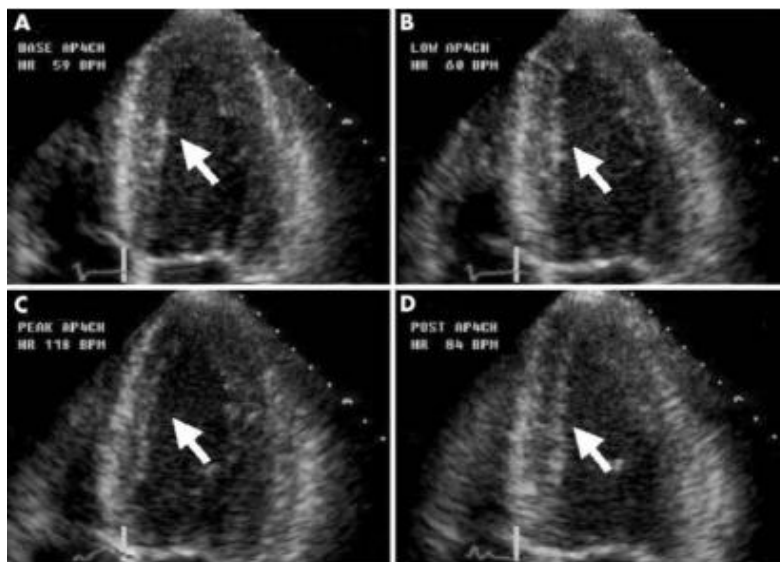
Echocardiographic images to observe wall motion abnormality. (A) Rest condition, (B) Low dose dobutamine applied image, (C) High dose dobutamine applied image, (D) Recovery condition.
